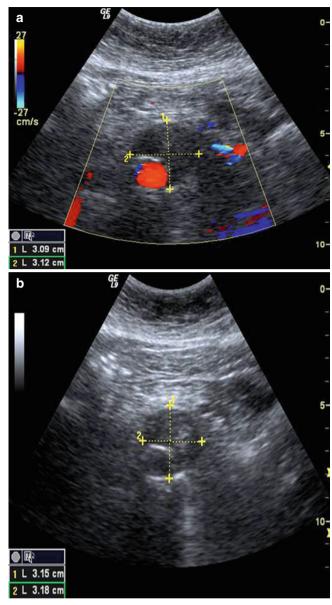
(a) Color Doppler, (b) B-mode; Cross-sectional view of residual aneurysm sac showing that the aneurysm has collapsed down around the stent
